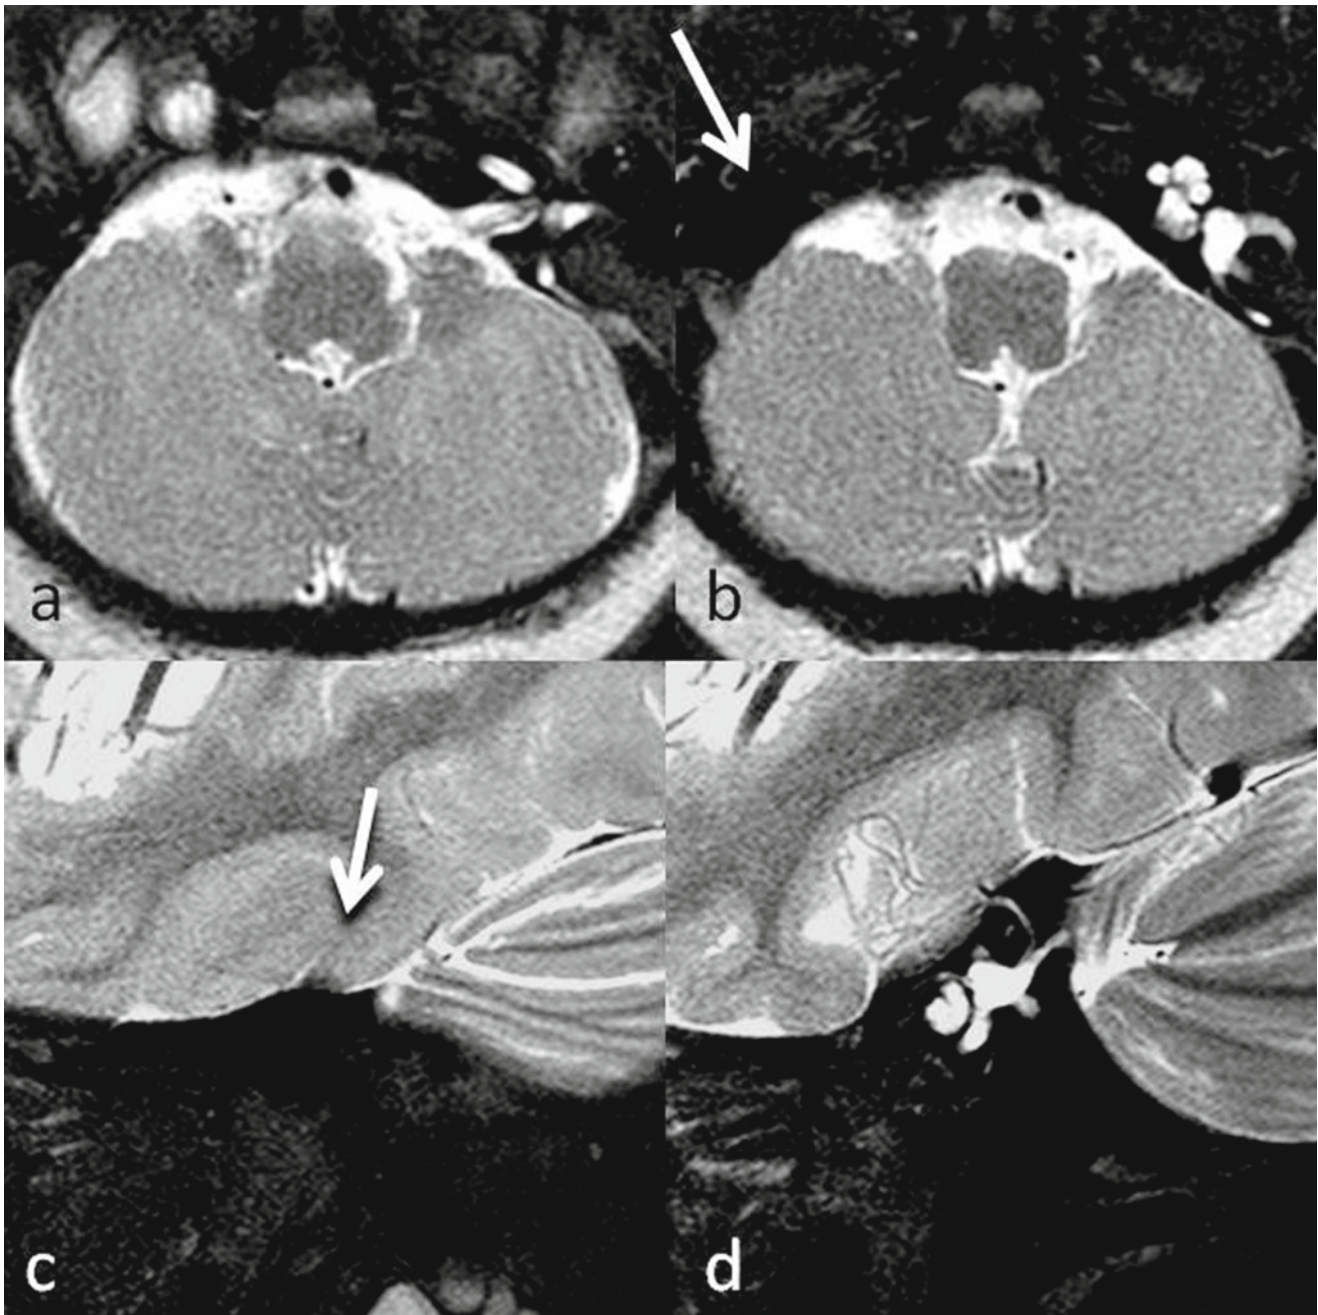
Newborn with complete absence of the right inner ear (Michel aplasia) as demonstrated by MRI. (a and b) Axial views demonstrating lack of development of right petrous apex, labyrinth and IAC (*arrow*). The left IAC and cochlea are normal. (c and d) Sagittal T2
